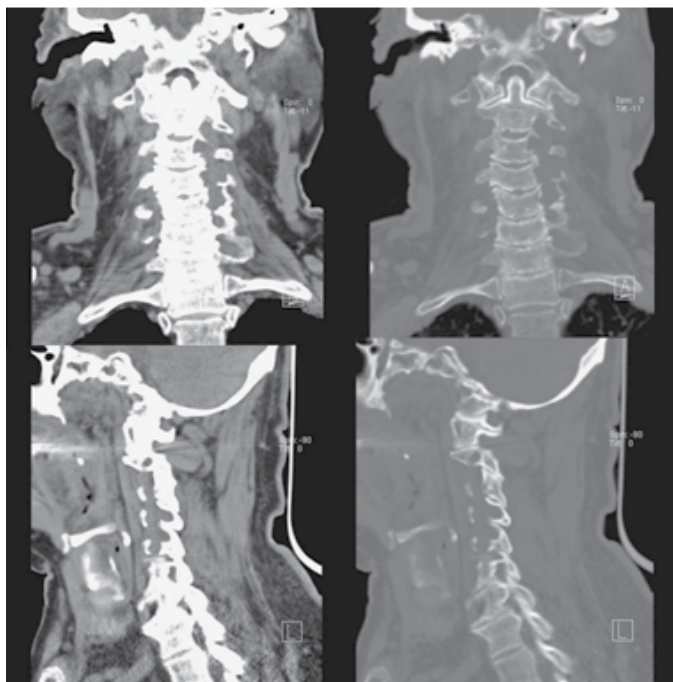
Preoperative C-spine computed tomography scan. Multiple foci of radiolucent and osteolytic lesions are noted over left lateral mass of C3, C4 and C5, as well as narrowing is found over left C3/C4, C4/C5 and C5/C6 neuroforamina.
